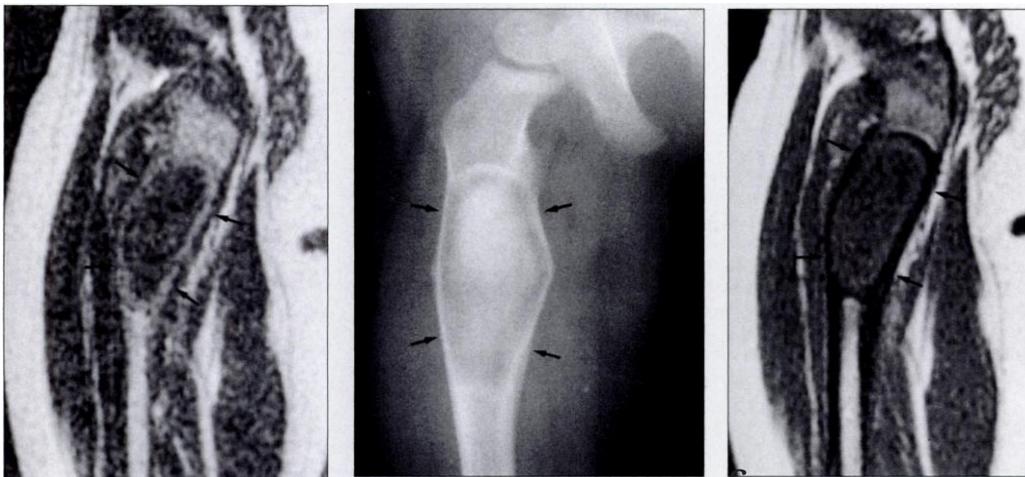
A. X-ray radiographs with radiolucent lesions with a well-defined sclerotic rim, B. T1WI, hypointense lesion, C. T2WI, hyperintense lesion.¹⁴
